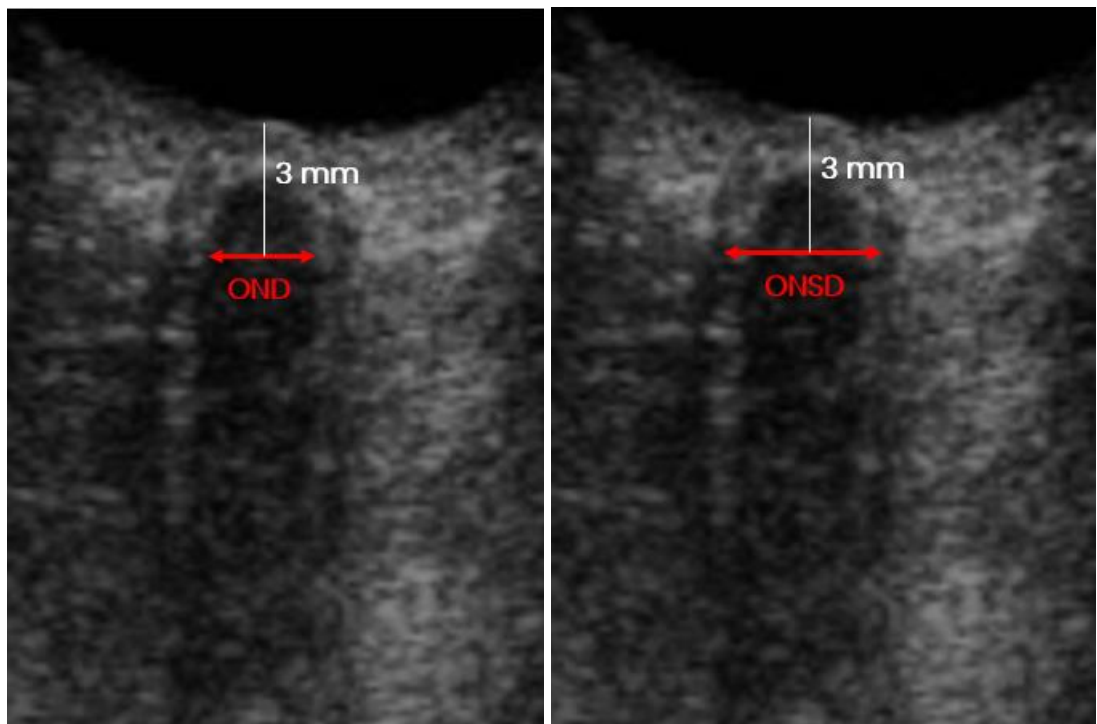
Appearance of optic nerve structures by transorbital sonography
